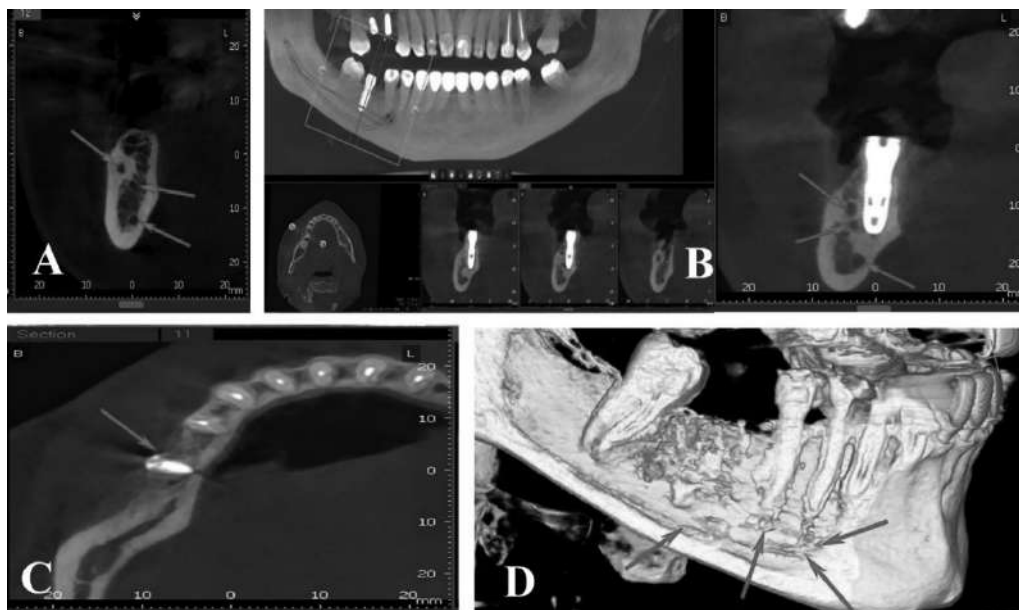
CT image of the lower jaw: A) sagittal section of the trifold variant of the mandibular canals; B) panoramic image and sagittal sections after subcortical implantation, taking into account the topographic and morphological features of the trifold manifestation of the mandibular canals; C) axillary section of the bicortical fixation of the barrier membrane after lateral augmentation, taking into account the topography of the mandibular canal; D) coronal (frontal) cross-section of a 3D reconstruction model of the mandibular canal system
